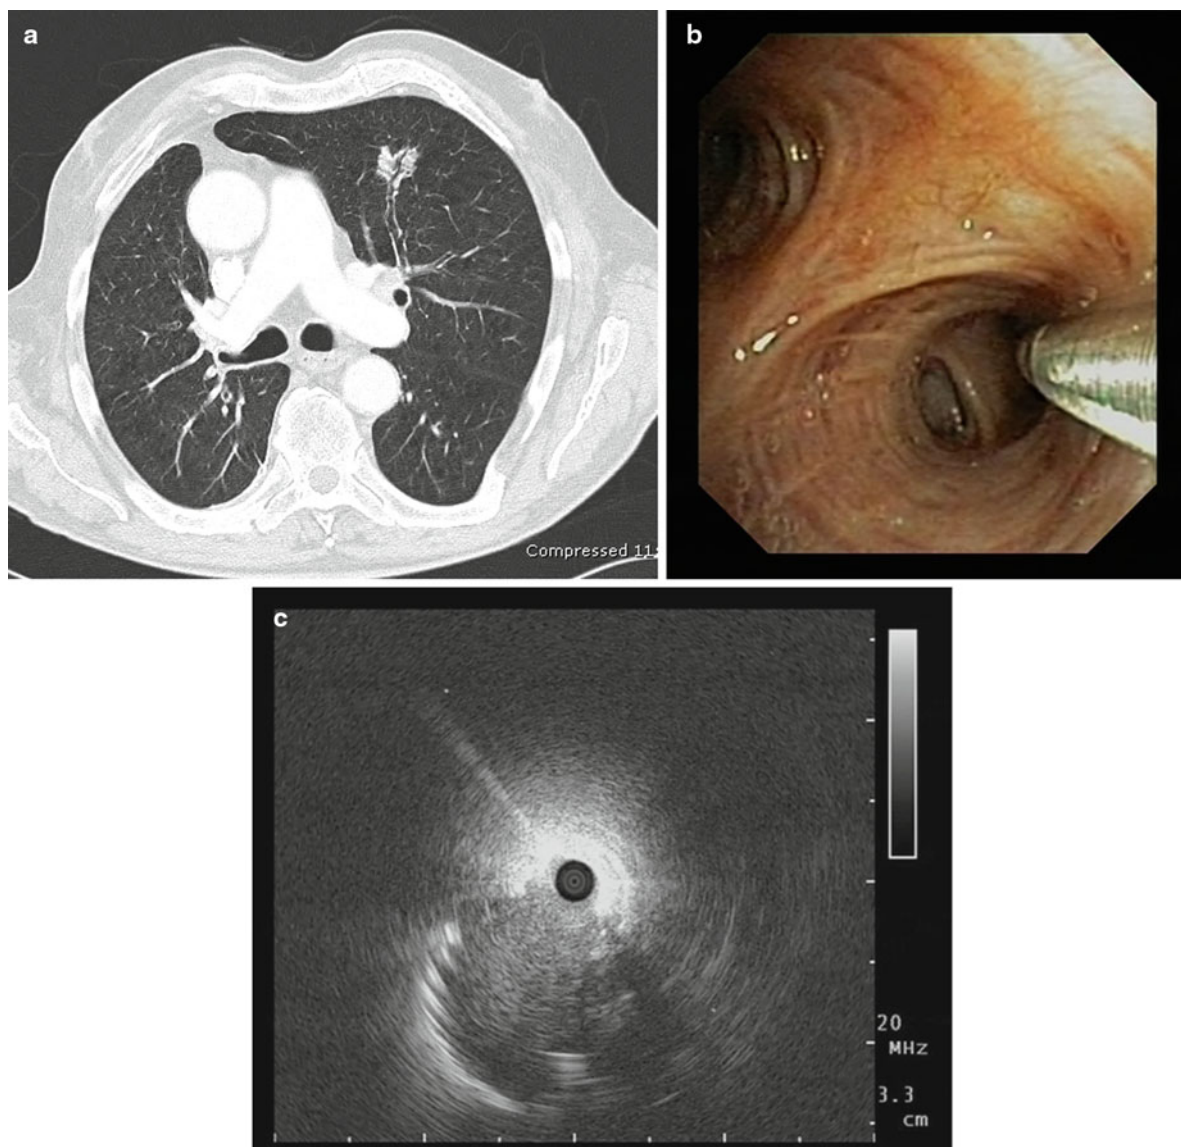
(a) Bronchus sign: a bronchus leads directly to the peripheral nodule in the left upper lobe; (b, c) after introducing the minimiprobe under endoscopic control in the anterior segmental bronchus, the lesion could be detected. Although the ultrasound probe could be placed only adjacent
